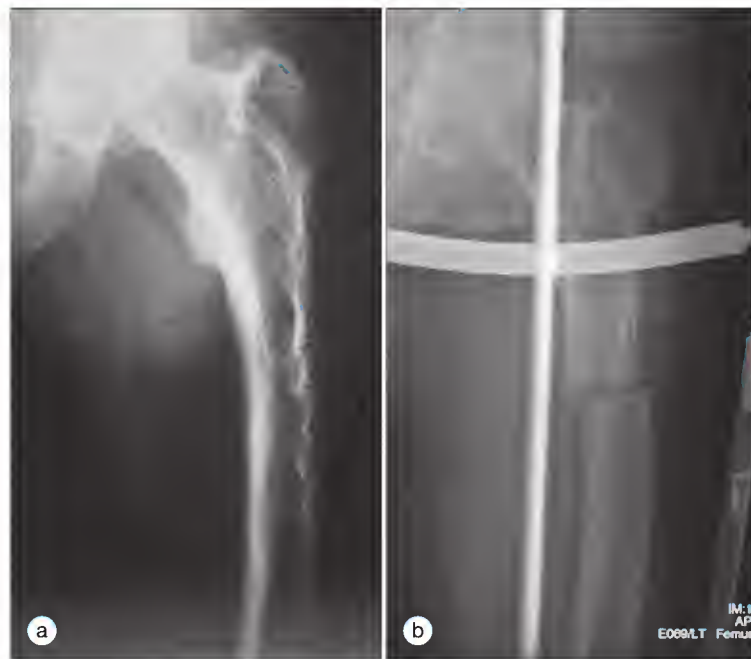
Lateral radiographs of the left femur before (a) and after (b) fracture. (a) Cortical incongruities or fissure fractures are present on the convex surface of this pagetic femur. They were asymptomatic for 15 years and showed no resolution with bisphosphonate treatment. (b) In 2005 the patient suffered an atraumatic fracture at this site. The fracture is a classic "chalk stick" fracture characteristic of Paget disease.
